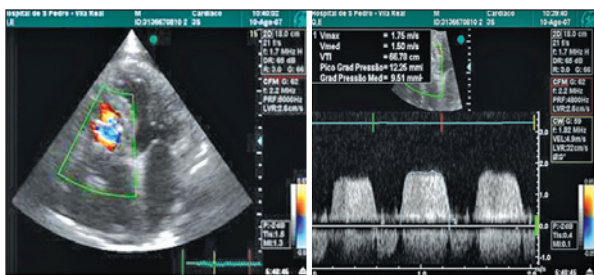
Transthoracic echocardiography with color flow Doppler revealing a severely dilated right atria with aliasing/turbulence of right ventricular inflow (left) and continuous wave Doppler demonstrating a mean TV gradient of 9.5 mmHg (right).
